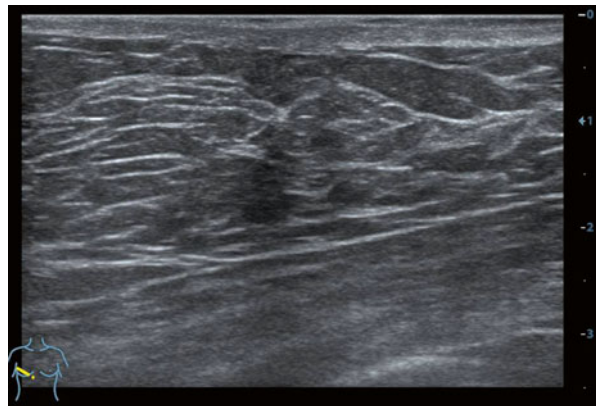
Normal ultrasound anatomy of the breast
